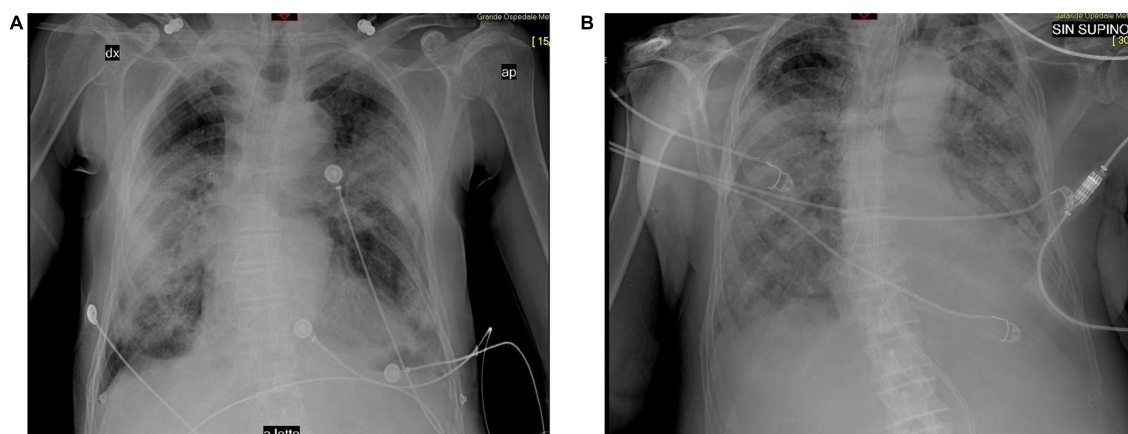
(A) Before the first administration of canakinumab, the chest X-ray shows interstitial changes, ground glass opacities, and multifocal and bilateral effusions. (B) After second administration, the chest X-ray shows the extensive bilateral opacities and bilateral effusions, concomitant to bacterial superinfection.
